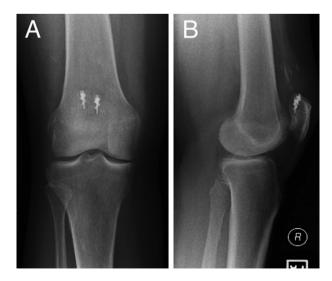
(A) Anteroposterior and (B) lateral radiographs following SA quadriceps tendon repair with two titanium anchors.
